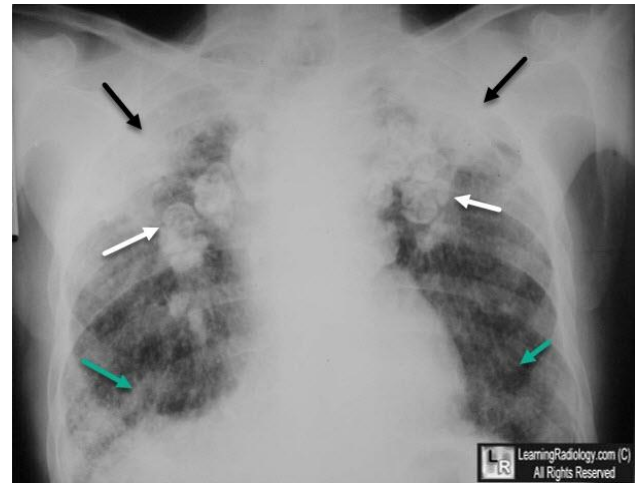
X-Ray of Silicosis: Progressive Massive Fibrosis with Egg Shell Features⁵
